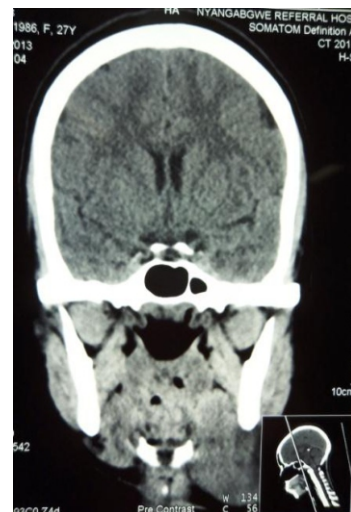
CT scan of submandibular region
